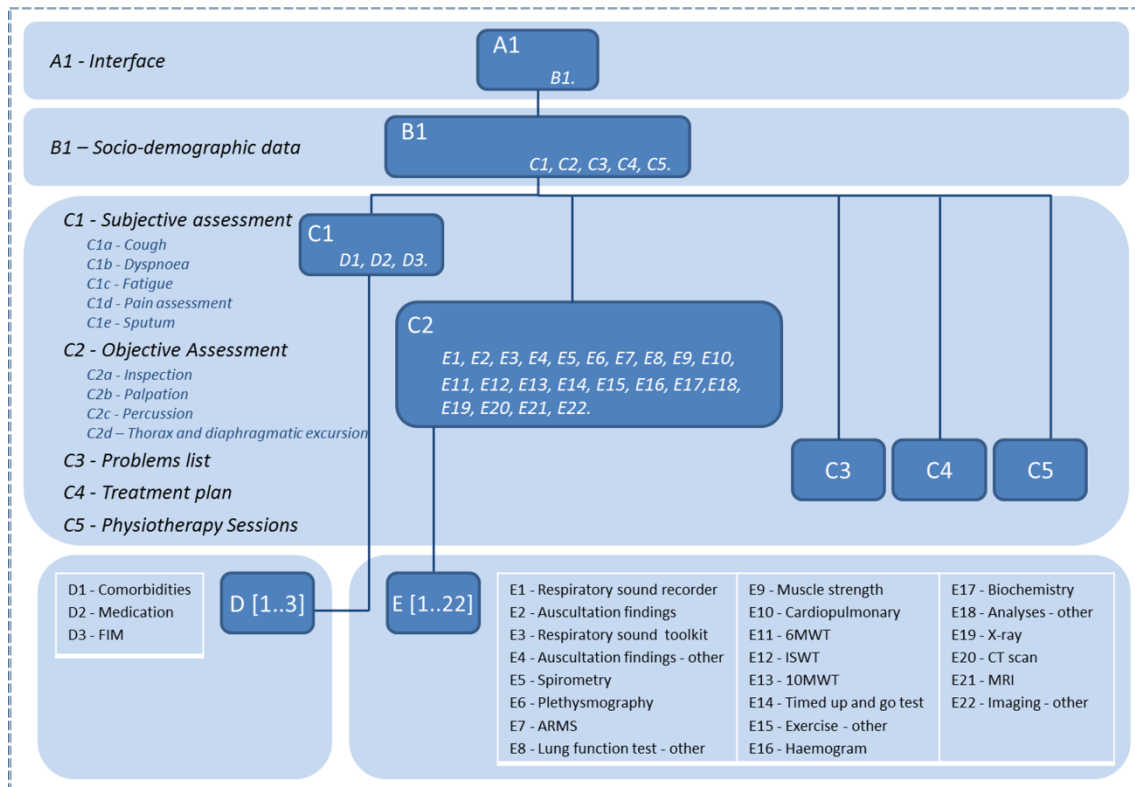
RIBS@UA interface structure – GUI composed by 42 windows, with a hierarchy of 4 levels. *FIM* - functional independence measure; *ARMS* - assessment of respiratory muscle strength; *6MWT* - 6 minute walk test; *ISWT* - incremental shuttle walk test; *10 MWT* - 10 meter walk test; *X-ray* - chest radiography; *CT* - computerised tomography; *MRI* - Magnetic resonance imaging.
